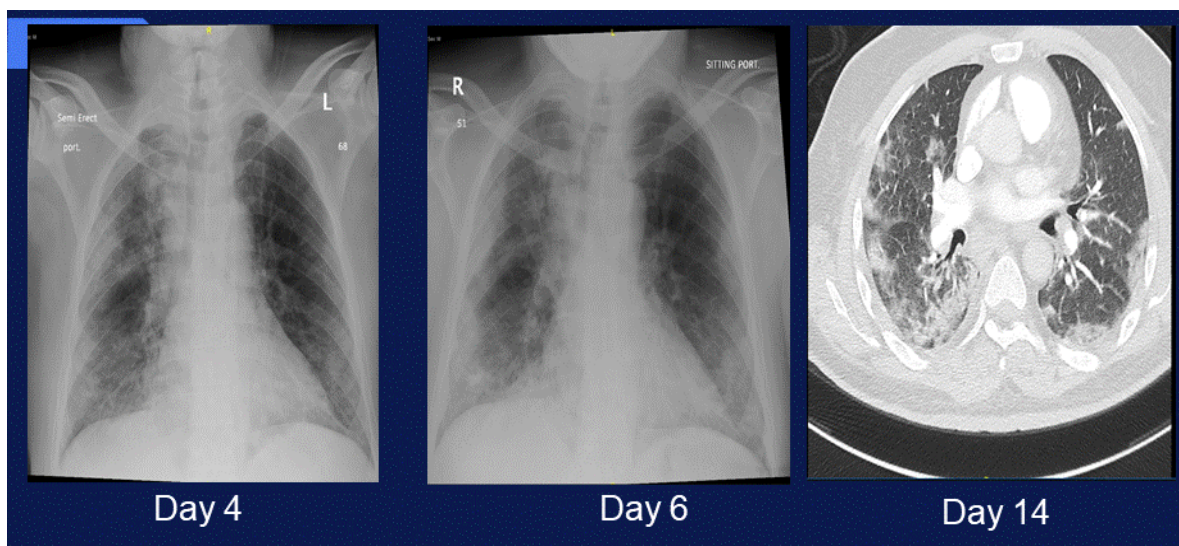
Chest-x-rays and a slice of CT Chest confirming bilateral mainly basal and peripheral interstitial infiltrate.
